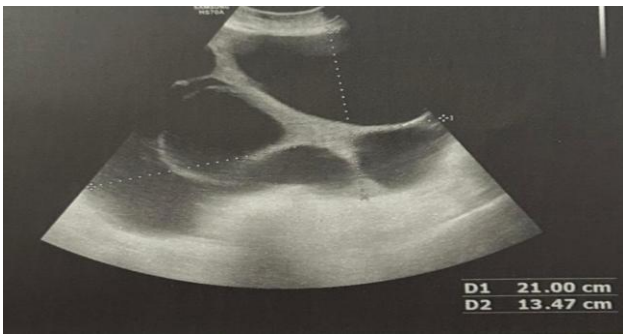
Ultrasound findings-multiloculated cystic lesion.
